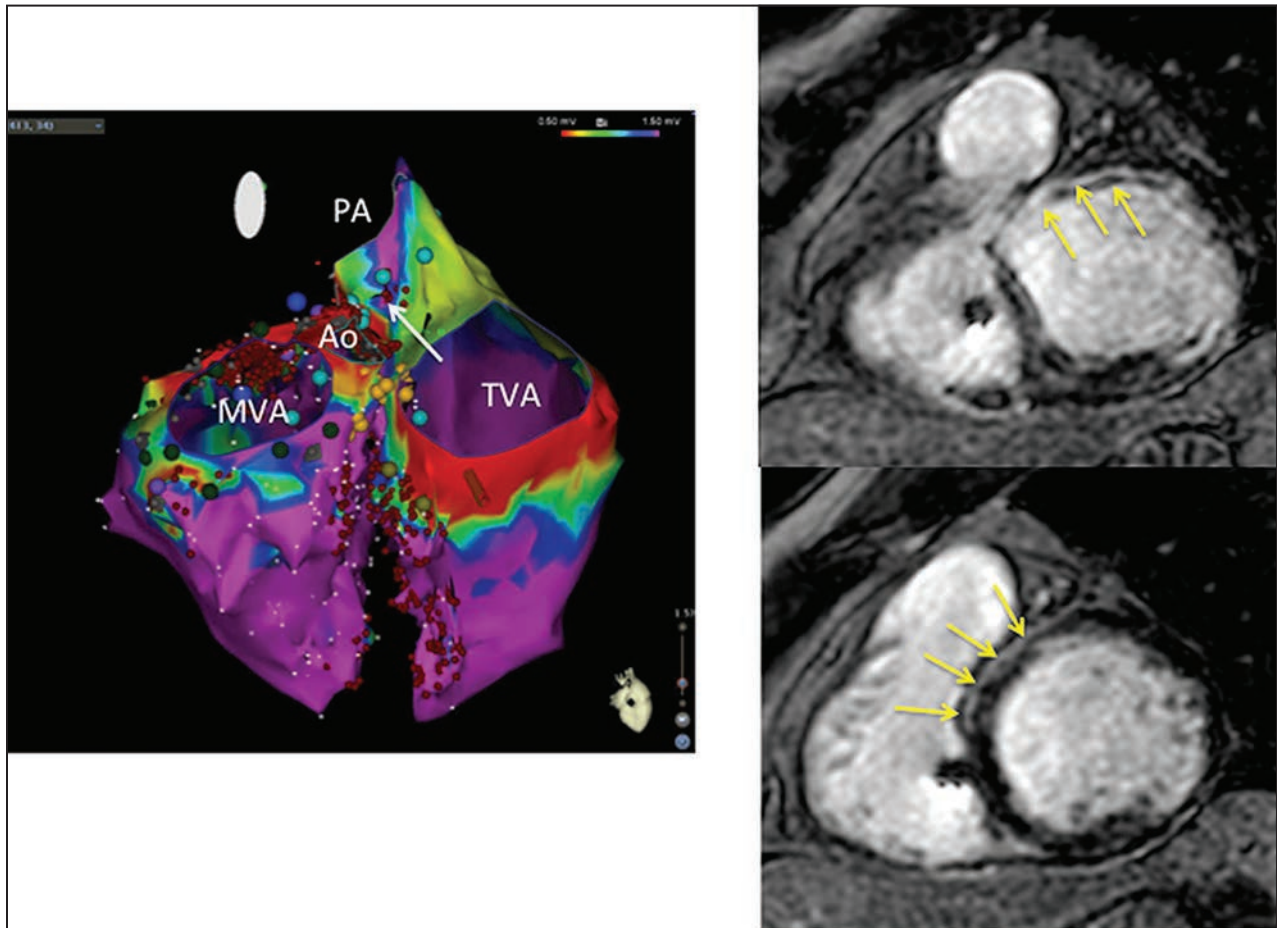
Left panel: 3D reconstruction of echocardiographic contours of right and left ventricles from a posterior view showing the mitral valve annulus (MVA), the aortic (Ao) valve, the tricuspid valve annulus (TVA), the pulmonary artery (PA), and a superimposed biventricular voltage map. A white arrow indicates the location of the site of pace mapping from Figure 23-2. Right panel: Biventricular short-axis view of CMR showing intramural scarring: The top panel indicates a basal and the bottom panel a more apical view. The intramural scar is indicated with yellow arrows.
